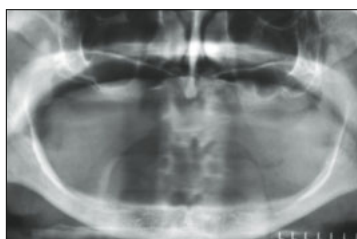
Radiographic analysis confirms the severe bone resorption of the maxilla, making it impossible to place standard implants in the posterior maxilla. The bone height was adequate for placing implants at the desired level in the anterior mandible.
